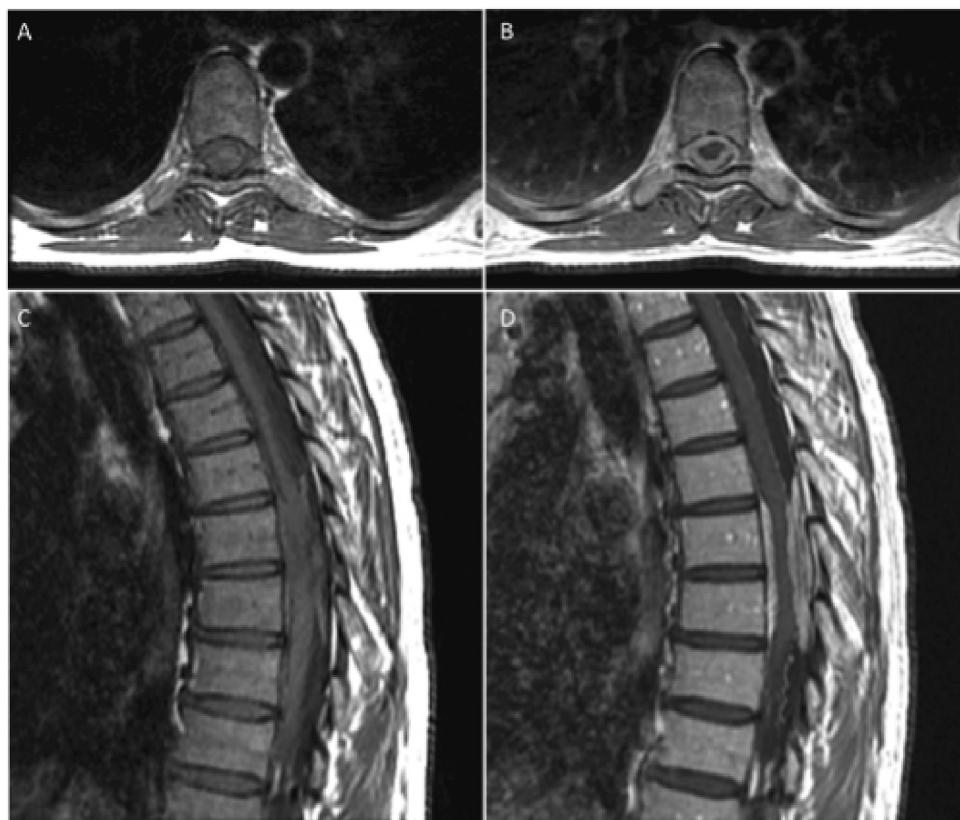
Magnetic resonance imaging of the spine. Sagittal T1 pre- (A) and post-gadolinium (B) contrast. Axial T1 pre- (C) and post-gadolinium (D) contrast administration. A circumferential soft tissue abnormality at T6 and T7 vertebral levels completely surrounds the spinal cord. Signal abnormality at T7 vertebral level indicates compression. This soft tissue abnormality is in the subdural space rather than the epidural compartment. The lesion contained reasonably uniform contrast enhancement (A and B as well as C and D). There was no extension beyond the dural tube to involve the exit foramina or the adjacent vertebral marrow. There are also some prominent vessels on the dorsal aspect of the spinal cord cranial and caudal to the lumbar cord compression most likely representing congested veins. No other levels are involved.
